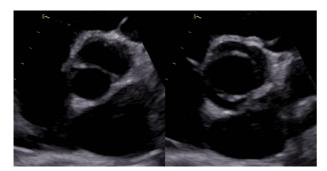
Transthoracic echocardiographic image of bicuspid aortic valve in diastole (left) and in systole (right), revealing the clear fishmouth appearance of the bicuspid aortic valve orifice.
